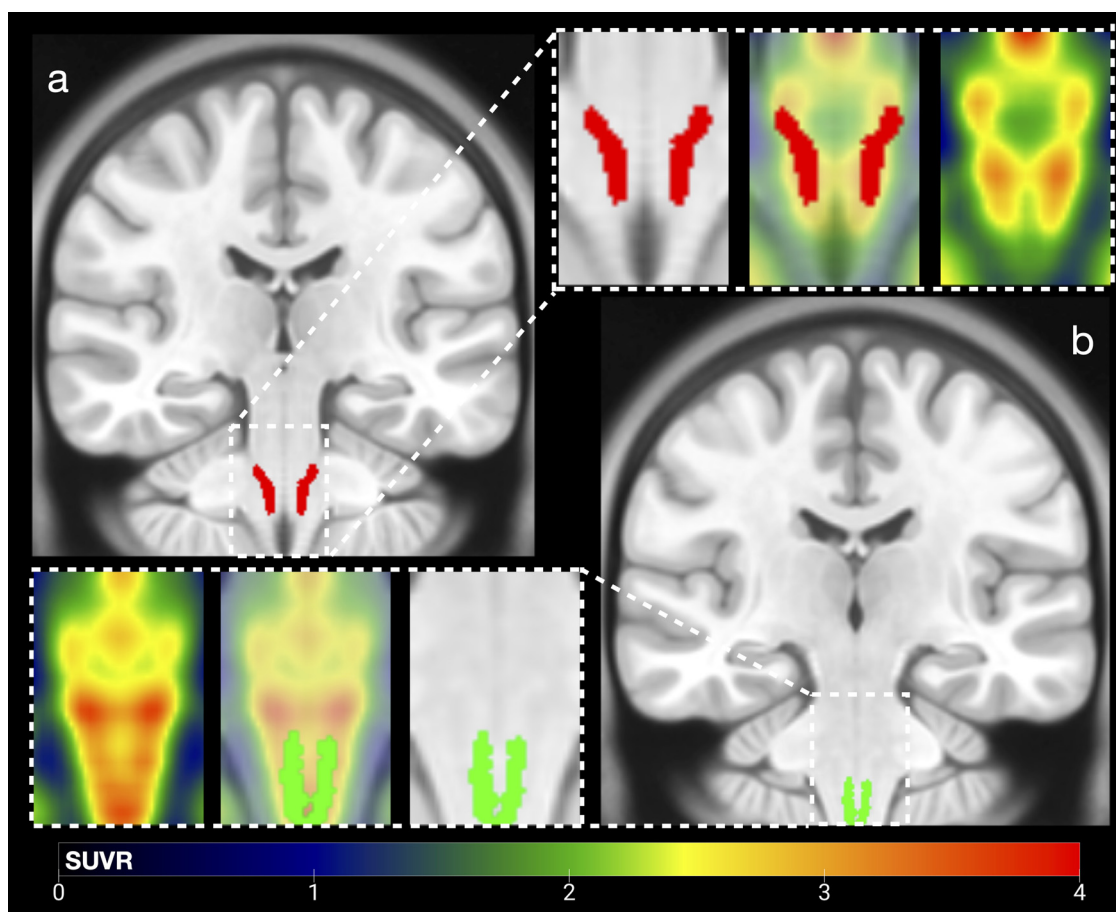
Distribution of $[^{18}\text{F}]$ FEOBV PET in the medulla oblongata and lower pons. Atlas from the Brainstem Navigator toolkit are superimposed on an average $[^{18}\text{F}]$ FEOBV PET of 20 healthy controls overlaid on a coronal section of the MNI space template. The vestibular nuclei complex (a, red) including the medial vestibular nucleus, and the viscerosensory-motor nuclei complex (b, green) including the dorsal motor nucleus of the vagus and hypoglossus are displayed. All images angled perpendicular to the pontomesencephalic junction. Red colour indicates SUVR of 4 or higher.
